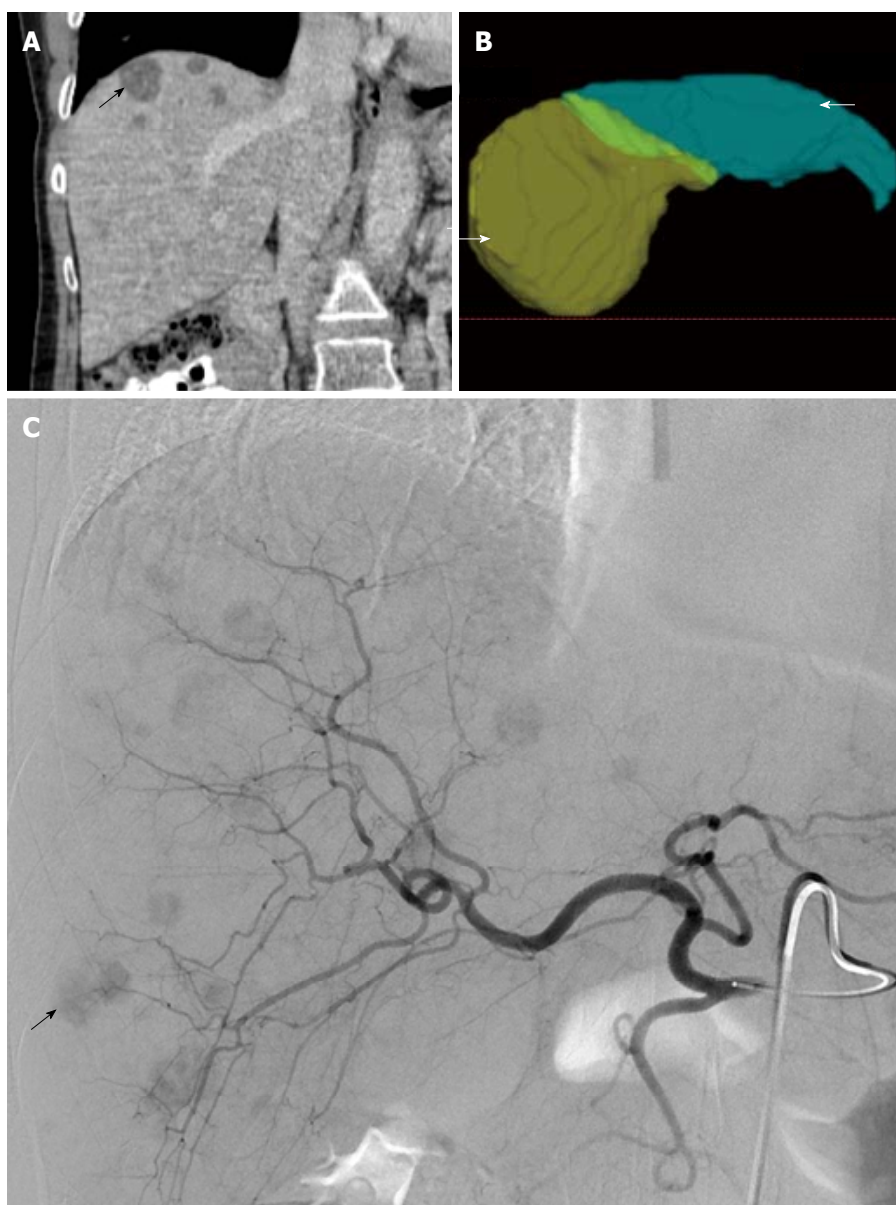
Yttrium-90 planning and radioembolization for treatment of liver metastases from adrenocortical carcinoma. A: Representative coronal CT abdomen image obtained prior to locoregional therapy shows low density lesions within the liver (arrow) consistent with metastatic disease; B: Three-dimensional reconstructions of the liver used for Yttrium-90 dose calculations revealed a proposed treatment volume of 409 mL for the left hepatic lobe (green colored, arrow) and 1339 mL for the right hepatic lobe (yellow colored, arrowhead) for a total hepatic volume of 1749 mL; C: Digitally subtracted contrast angiography reveals numerous hypervascular metastases within the right and left hepatic lobes (representative right hepatic lobe lesion demarked by arrow).
